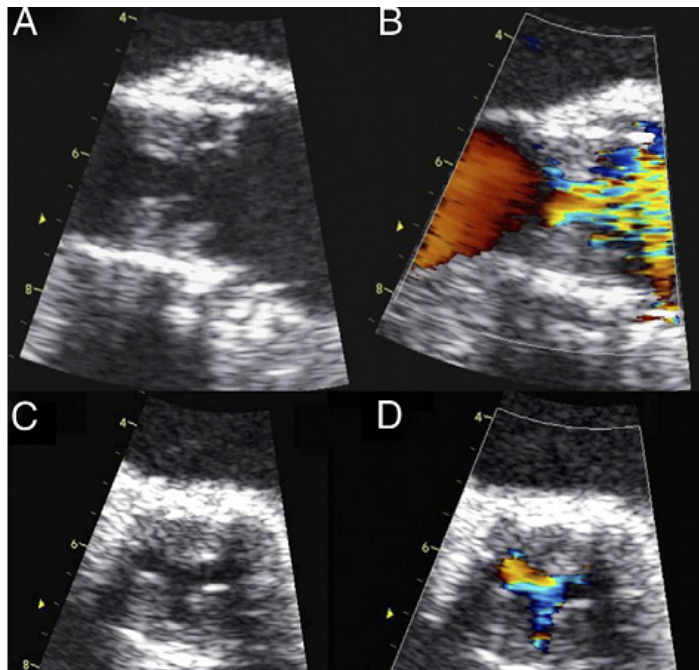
Echocardiographic Images of Aortic Valve and Graphical Representation of Mean Gradients
